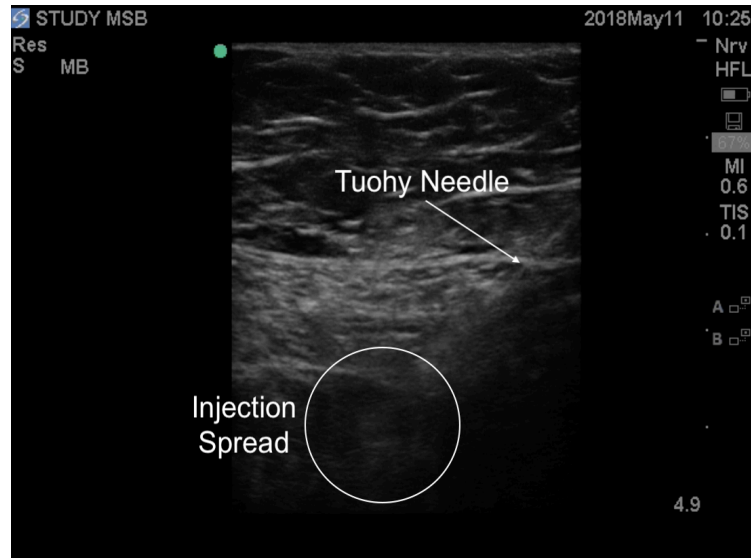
Ultrasound Image of the intermediate cutaneous nerve of the thigh injection
